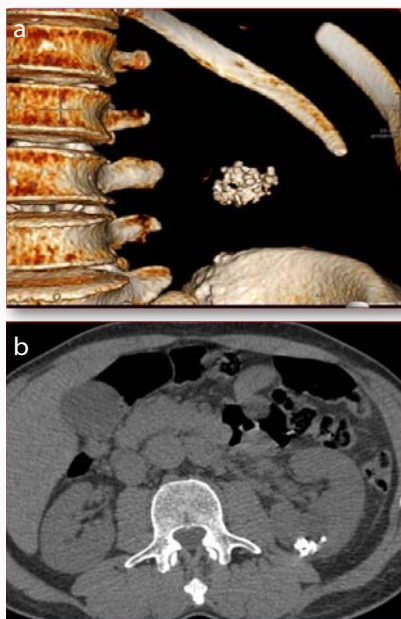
a) A 3D reconstruction of CT image. b) An Axial image of a basal CT. A cortico-subcortical cystic lesion of 3.5 cm with calcifications inside is described.
